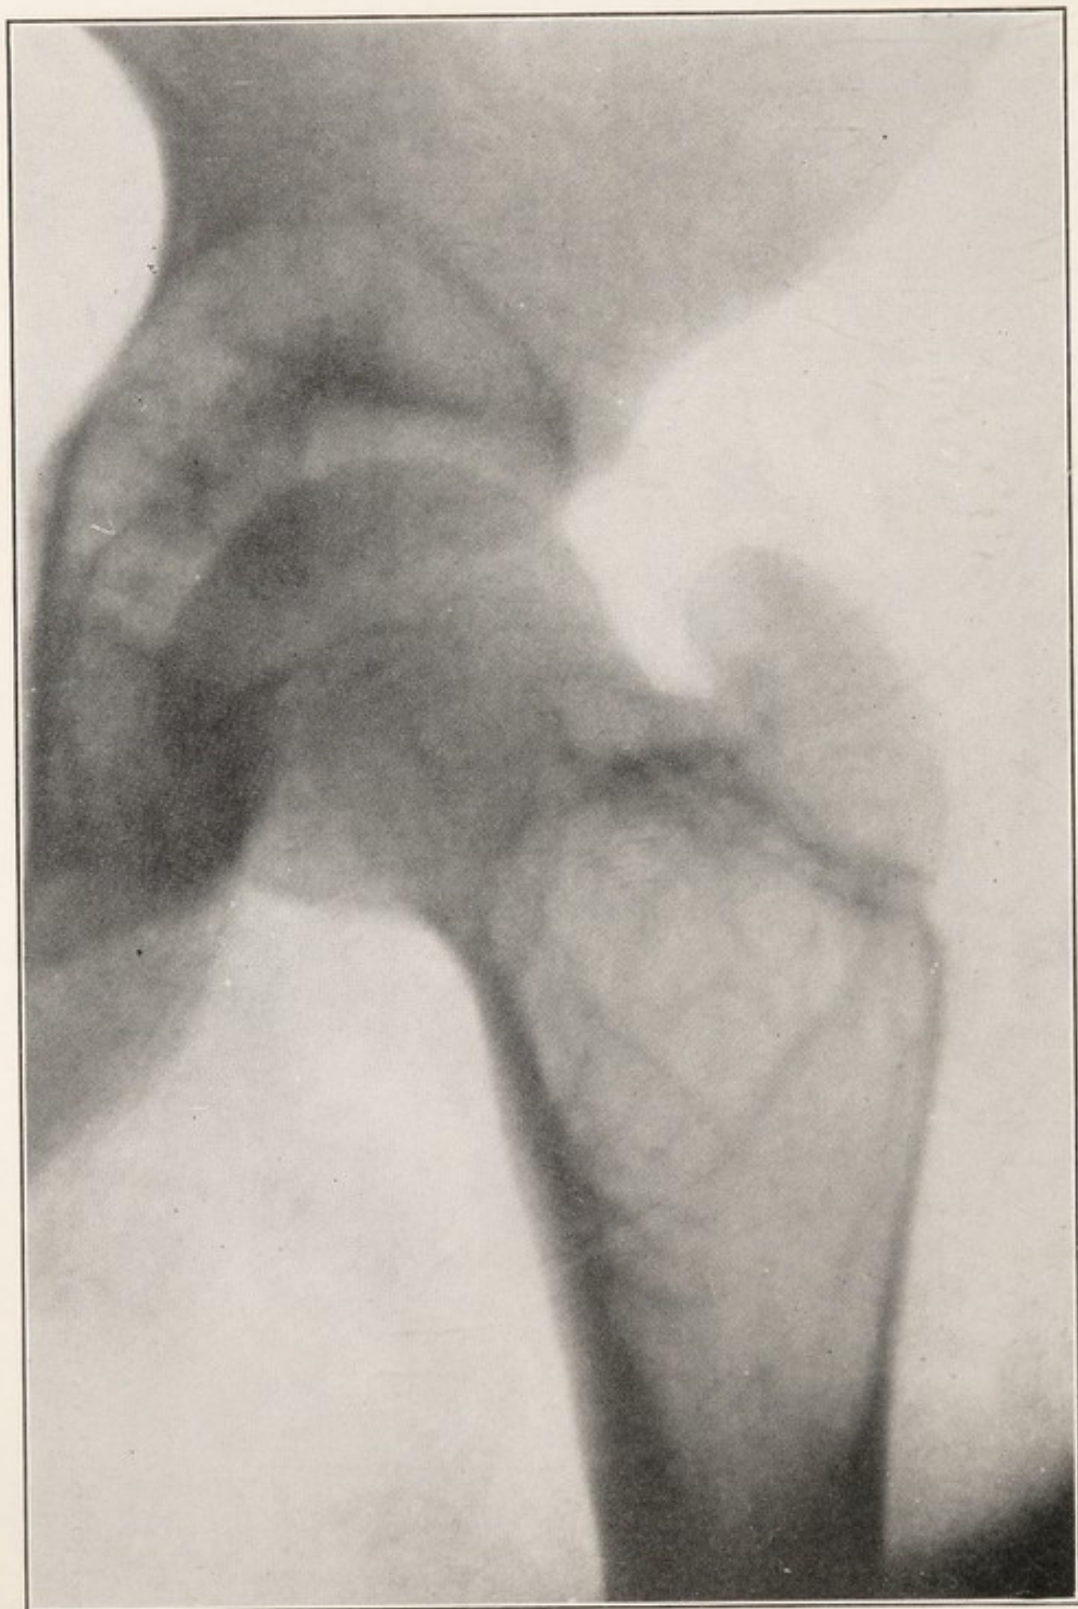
X-RAY OF OSTEITIS FIBROSA CYSTICA OF UPPER END OF FEMUR, SHOWING MULTILOCULAR CYST WITHOUT EXPANSION OF BONE CORTEX.
